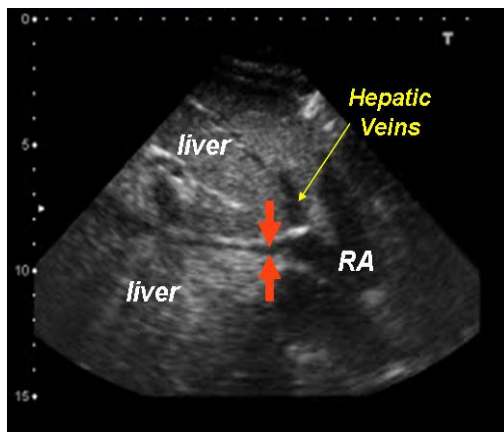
2D echocardiogram (subcostal view) in a shocked patient. In this patient who is breathing spontaneously the IVC (arrowed) collapses on inspiration, suggesting severe hypovolaemia.
